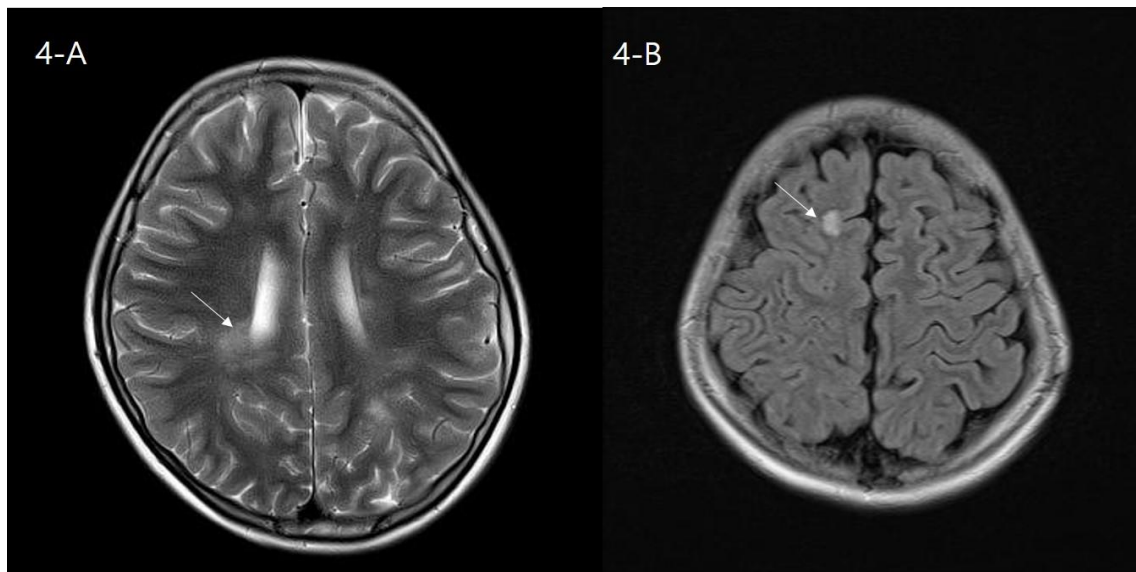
Brain MRI of patient 34 diagnosed with MS (MOG antibodies positive). Periventricular lesions are shown on the T2 weighted image (A). The T2 FLAIR shows juxtacortical lesions (B). MRI, magnetic resonance imaging; MOG, myelin oligodendrocyte glycoprotein; FLAIR, fluid-attenuated inversion recovery
